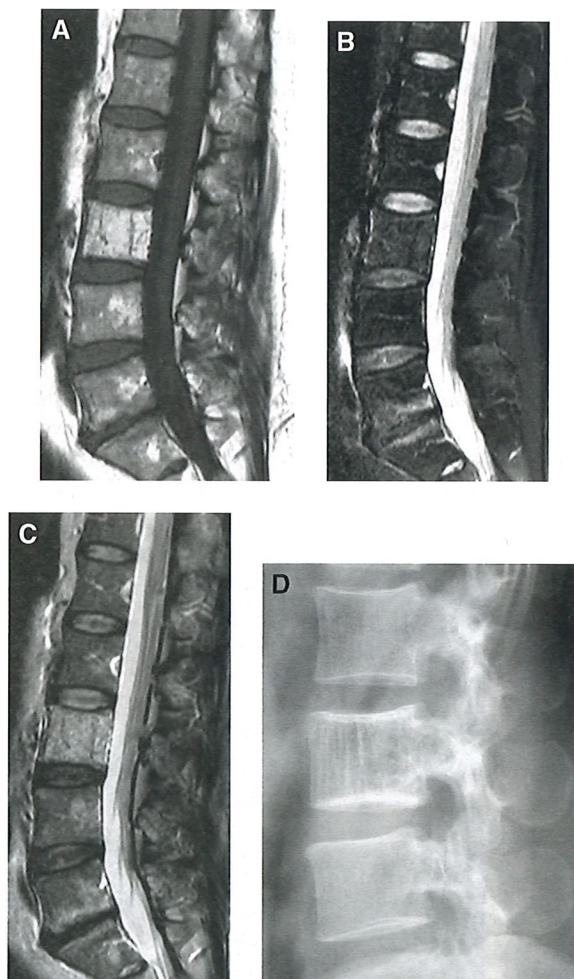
Typical vertebral hemangioma. (A) Sagittal T1-weighted SE, (B) T2-weighted FSE, and (C) fat-saturated intermediate-weighted FSE images of the lumbar spine of a 54-year-old woman shows marrow change in the L3 vertebral body with high signal on T1, intermediate signal on T2, and subtle increased signal on fat-saturated intermediate-weighted FSE images suggestive of a vertebral hemangioma. (D) Lateral radiograph of the spine shows thickened vertical trabeculae without vertebral hypertrophy suggestive of vertebral hemangioma.
